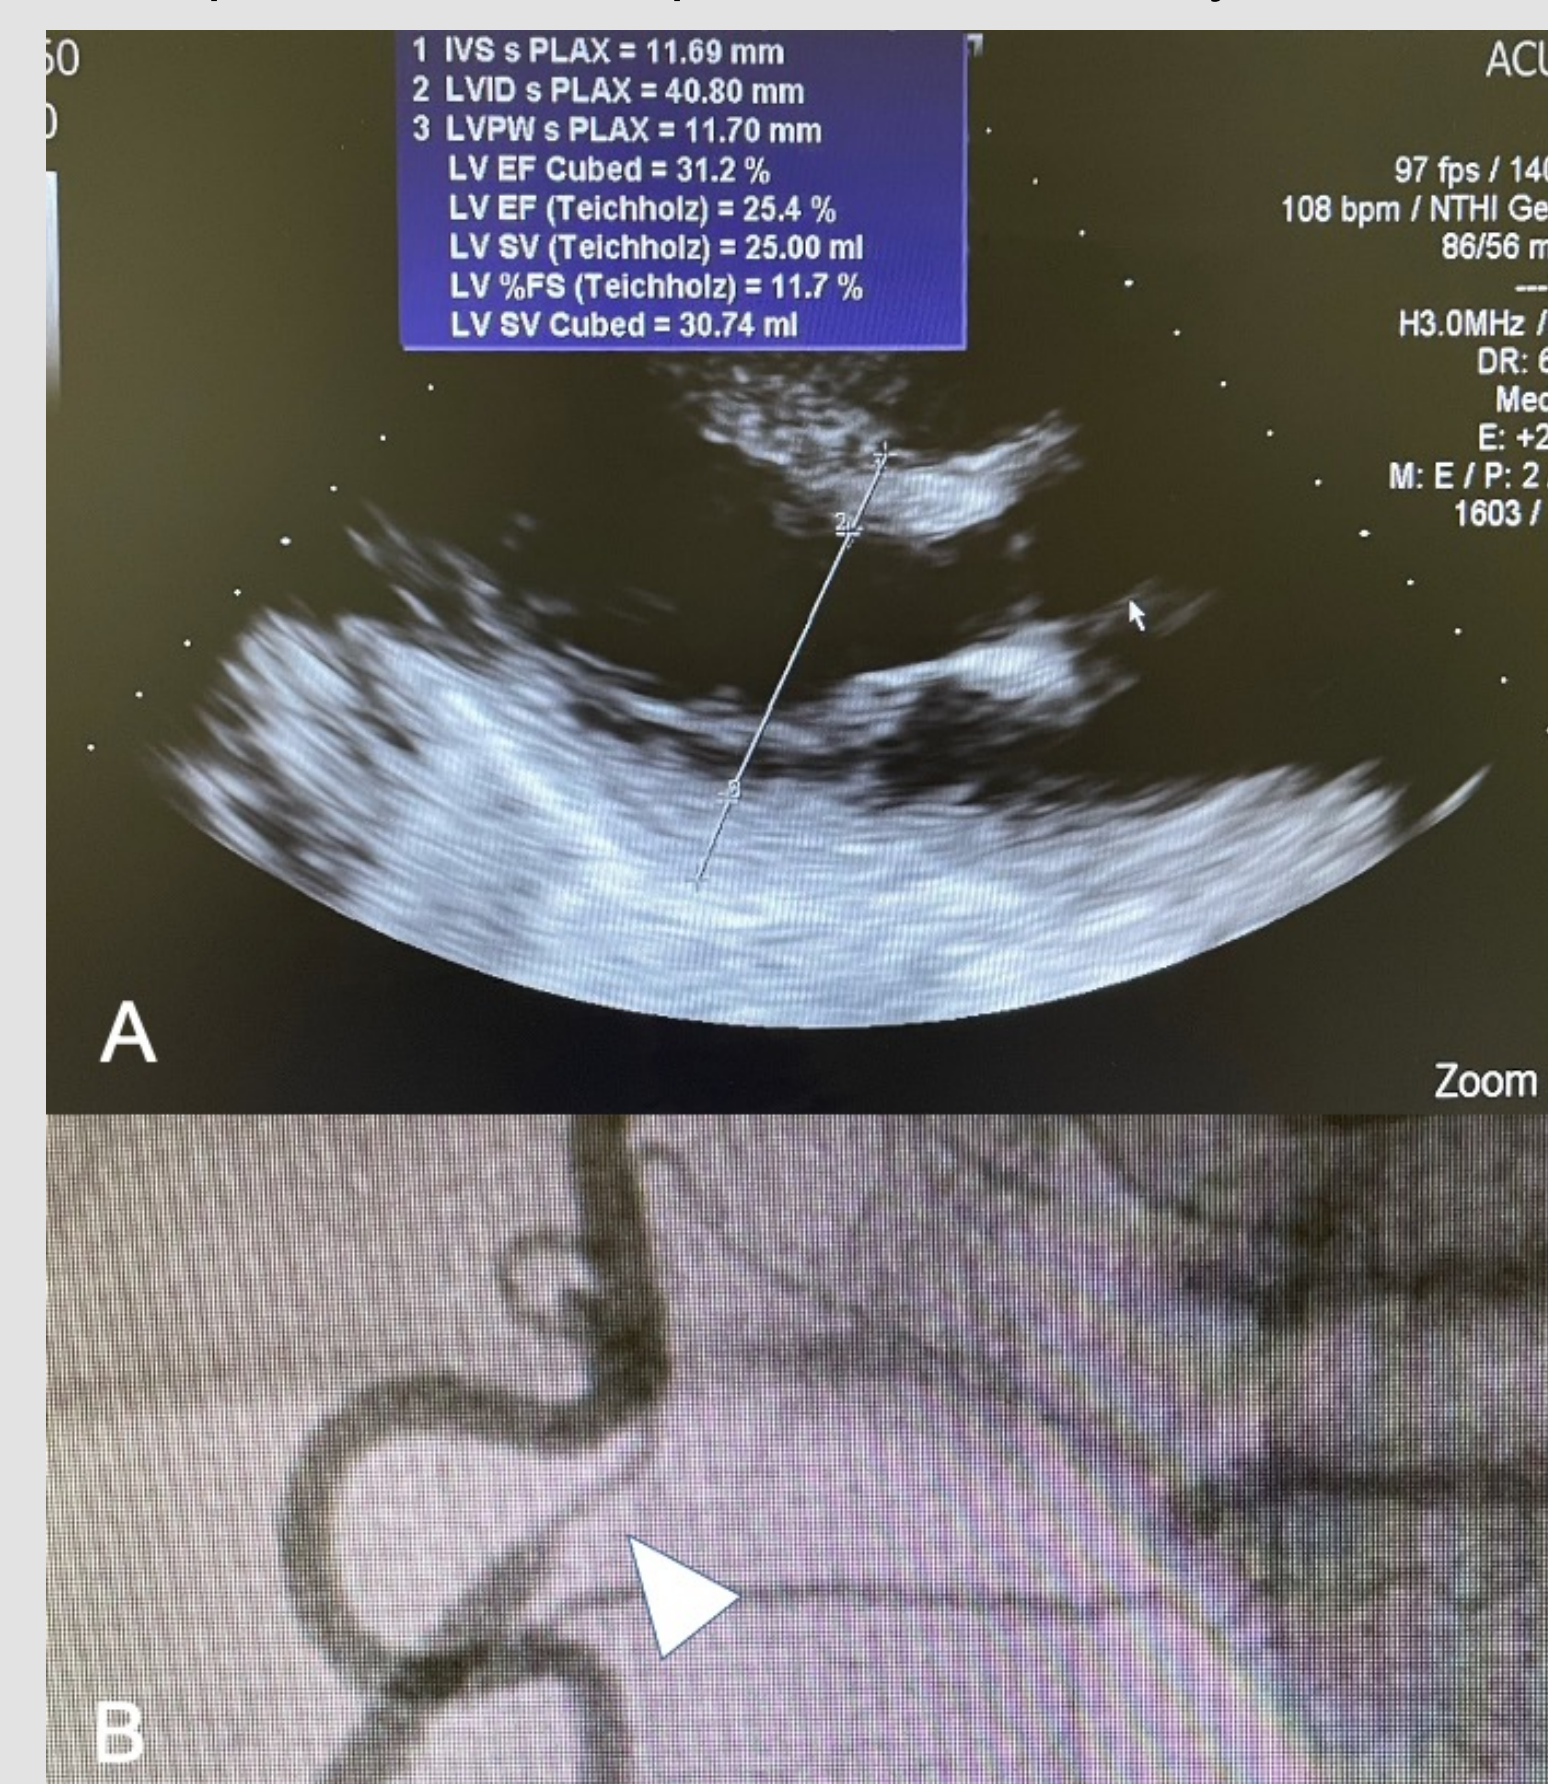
(A) 2D Echocardiogram showing LV EF 25.4%. (B) Coronary angiography showing lesion in mid-RCA (white arrowhead).
